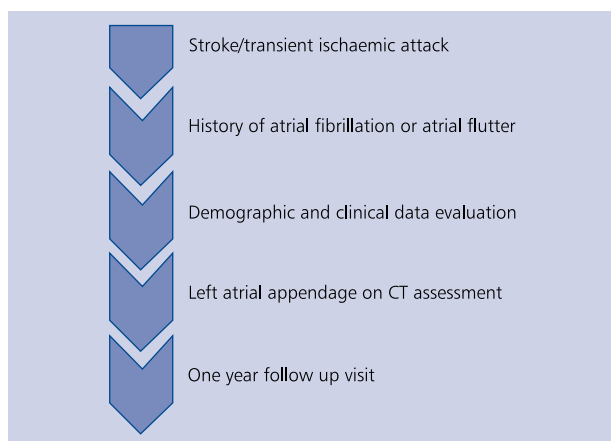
Design of the study; CT — computed tomography
